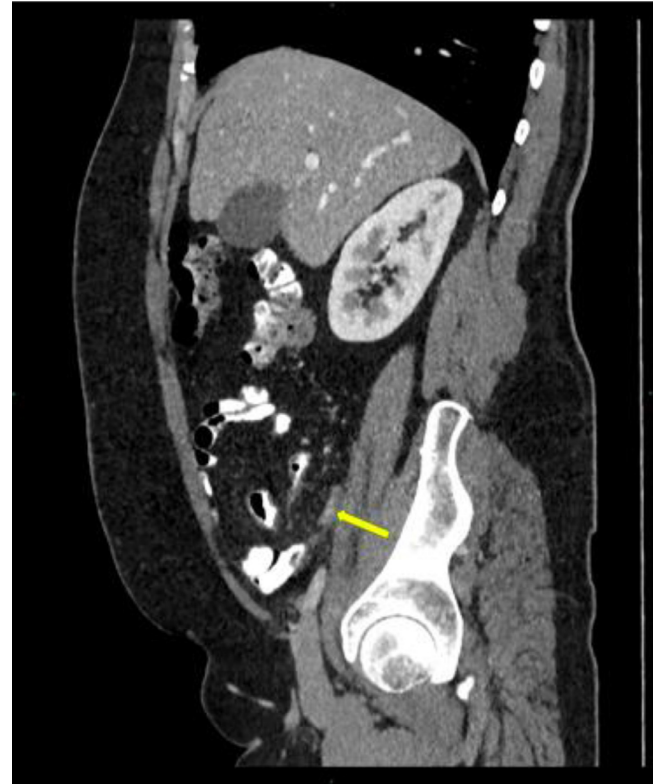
Contrast CT of the abdomen, sagittal reformation, demonstrates normal appendix (yellow arrow).
